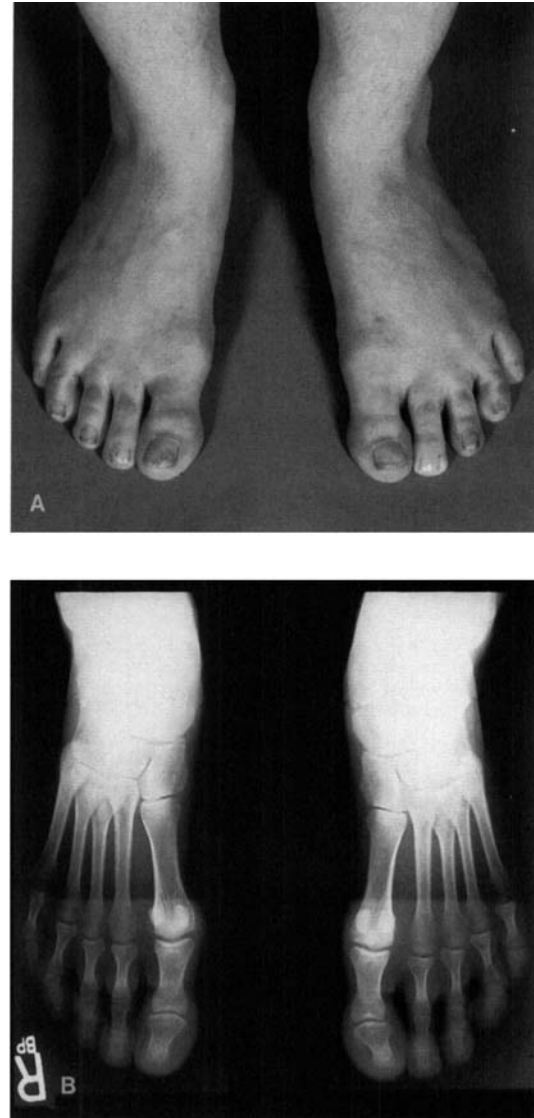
Clinical photograph (A) and roentgenogram (B) of the normal-appearing feet in the mother (II-3) of the affected girls.
